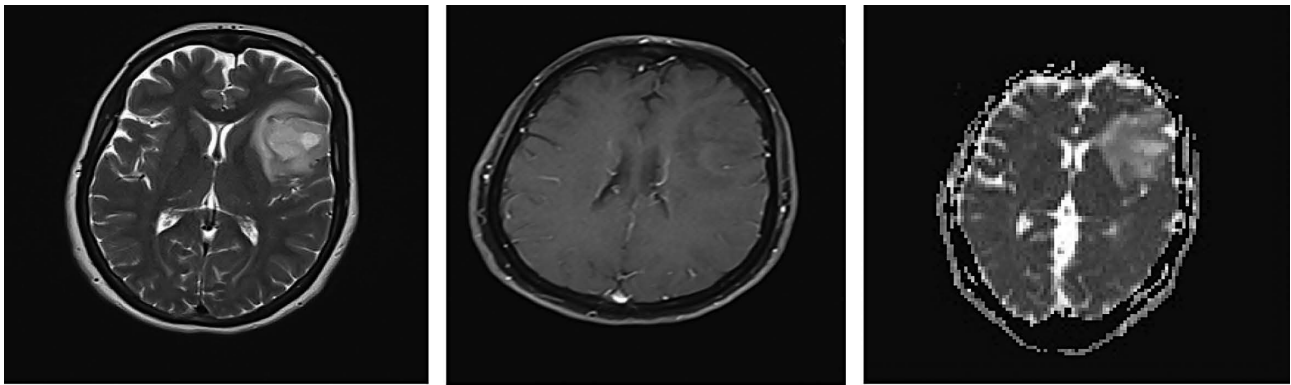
Astrocytoma grade II in 43-year-old woman. Transverse (a) preoperative T2-weighted MR image (3600/96), (b) contrast-enhanced T1-weighted MR image (440/14), and (c) ADC map show ill-defined tumor (arrows in a) in left insulo-opercular region. Irregular non enhancing area is noted in center of tumor (arrow in b). Minimum ADC value was $2.036 \times 10^{-3} \text{ mm}^2 \cdot \text{sec}^{-1}$.
